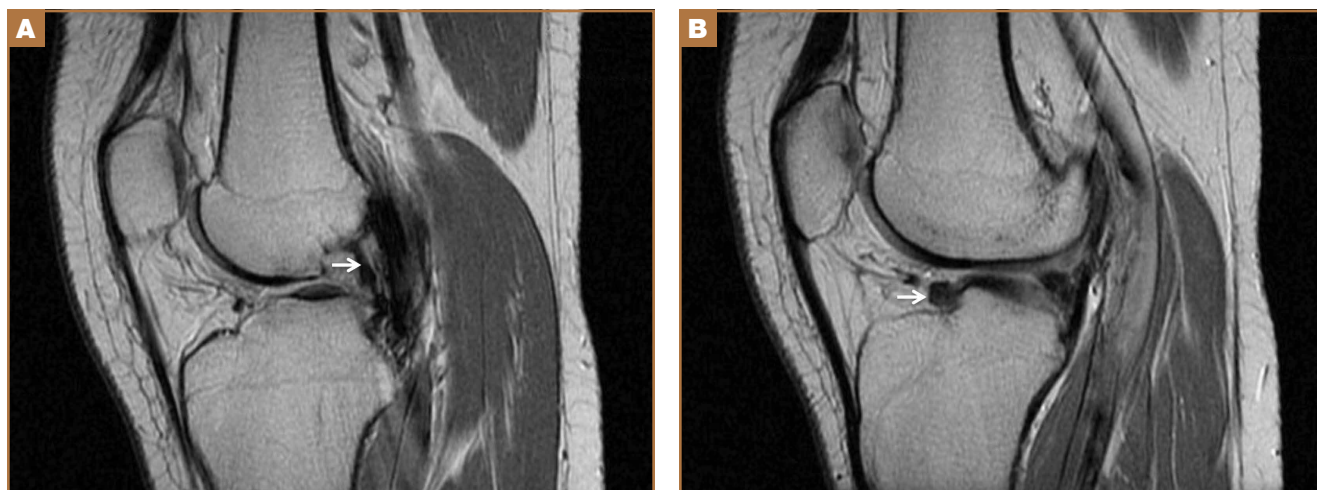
(A) Sagittal T2-weighted proton-density magnetic resonance imaging (MRI) shows a large meniscofemoral ligament of Humphrey (white arrow). (B) MRI shows small remnant of aplastic anterior cruciate ligament (white arrow).
